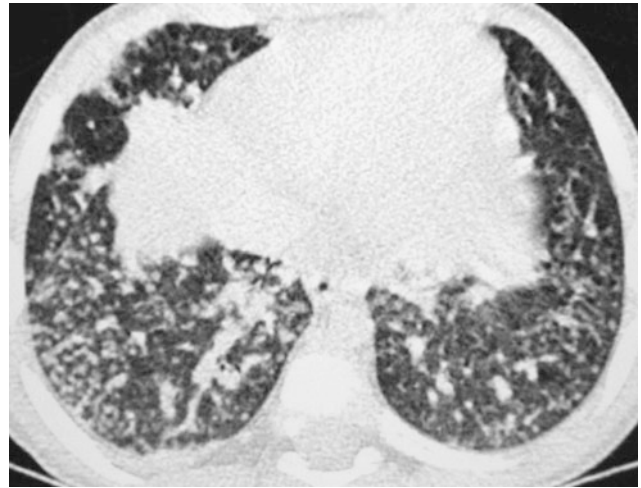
A 14-year-old girl with immotile cilia syndrome. HRCT shows centrilobular nodules, bronchiectasis, and peribronchial thickening
